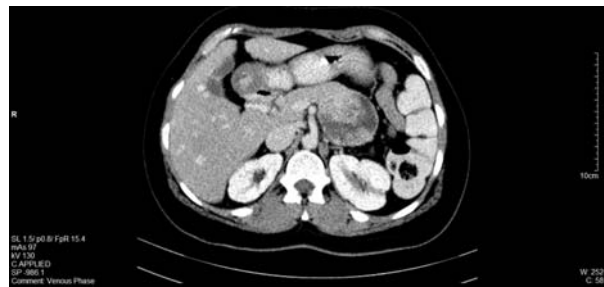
CT image of the SPT of the pancreas of the 36 year old female.
